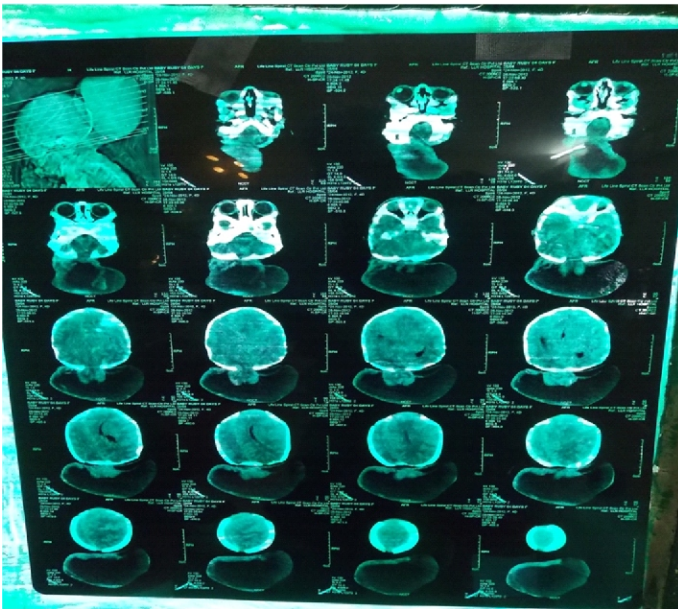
CT showing a large meningoencephalocele in occipital region
